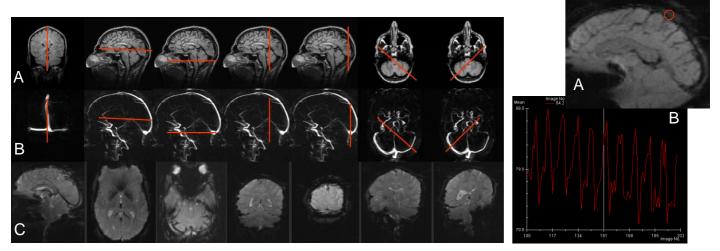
Seven standardized orientations of the single-slice BOLD acquisitions referenced to (A) 3D-FLAIR and (B) 2D phase-contrast angiography. (C) The corresponding BOLD images.
